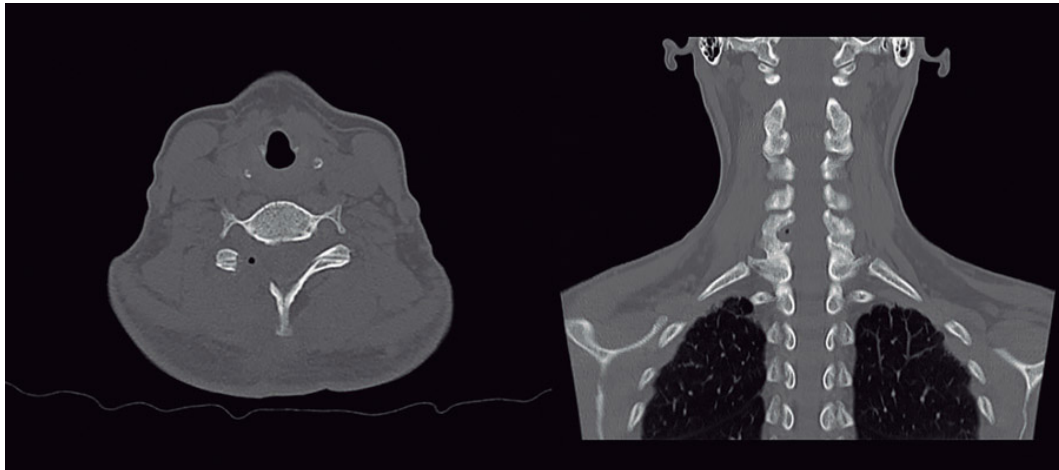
Postoperative axial and coronal CT demonstrates keyhole right foraminotomy with less than 50% of lateral mass for facet remotion.
